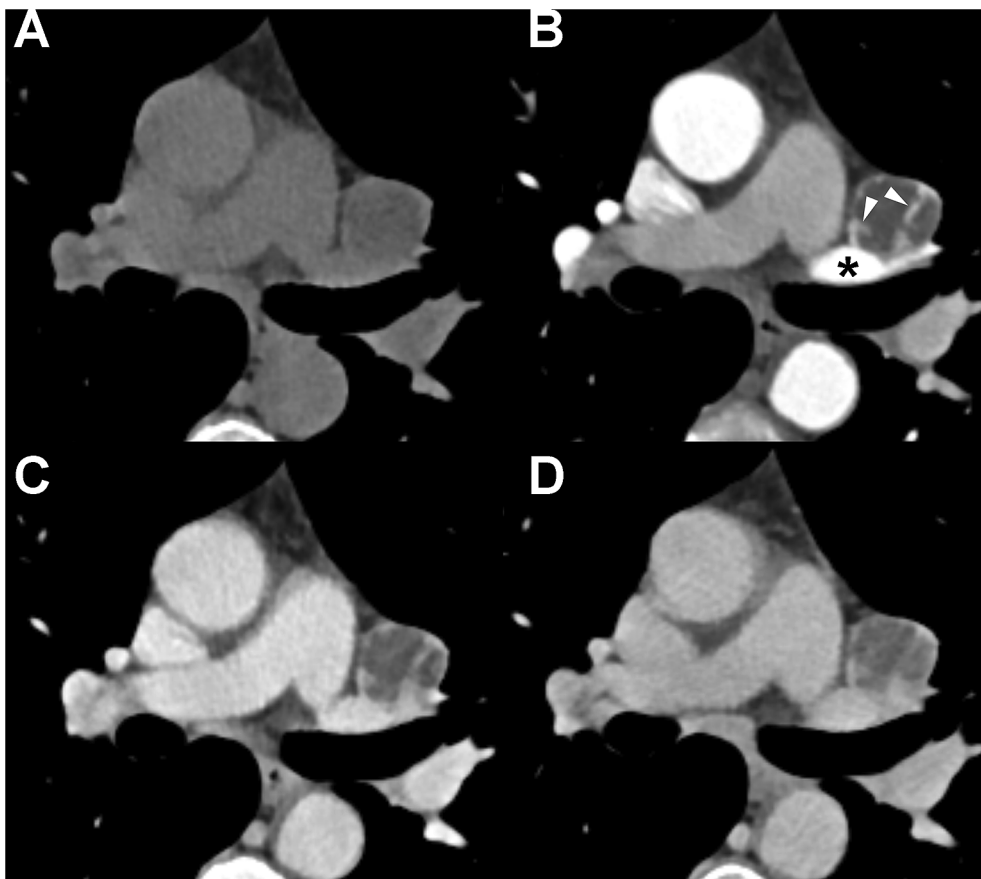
Axial dynamic contrast-enhanced CT images obtained before contrast medium injection (A), at 30 seconds (B), 1 minute (C) and 3 minutes (D) after contrast medium injection show that the nodule has predominant fluid attenuation with rim enhancement and thick hypervascularized septa (arrowheads in B). Note that the lesion is closely abutted to the superior pulmonary vein (asterisk in B).
